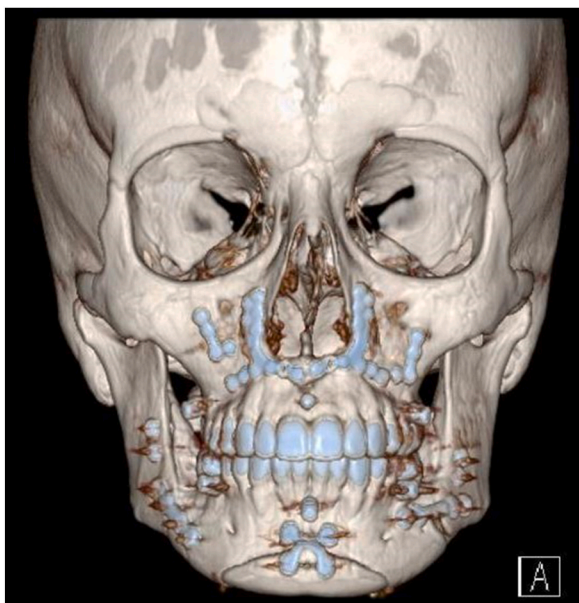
Computed tomography indicates successful stabilization of the osteotomy and a stable occlusion.
